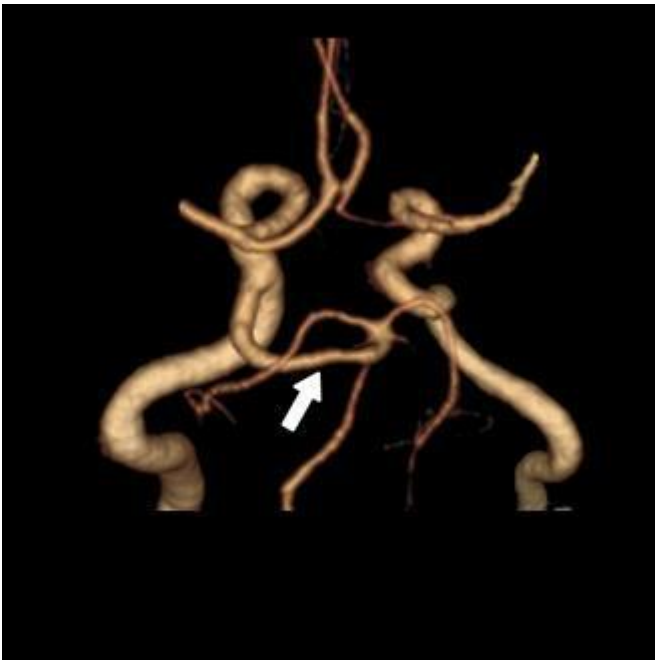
3D CT angiogram showing PTA (arrow) arising from the right ICA. (Image courtesy of babymhospital.org).
